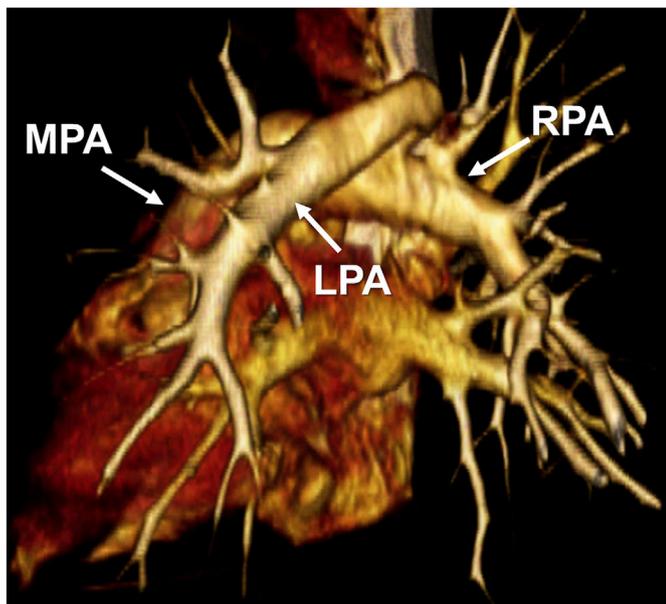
Three-dimensional virtually reconstructed computed tomography image of the left pulmonary artery sling - the lateral and posterior view. MPA – the main pulmonary artery, RPA - the right pulmonary artery, LPA – the left pulmonary artery. Philips Brilliance CT, 40 slice, 140 kV.
